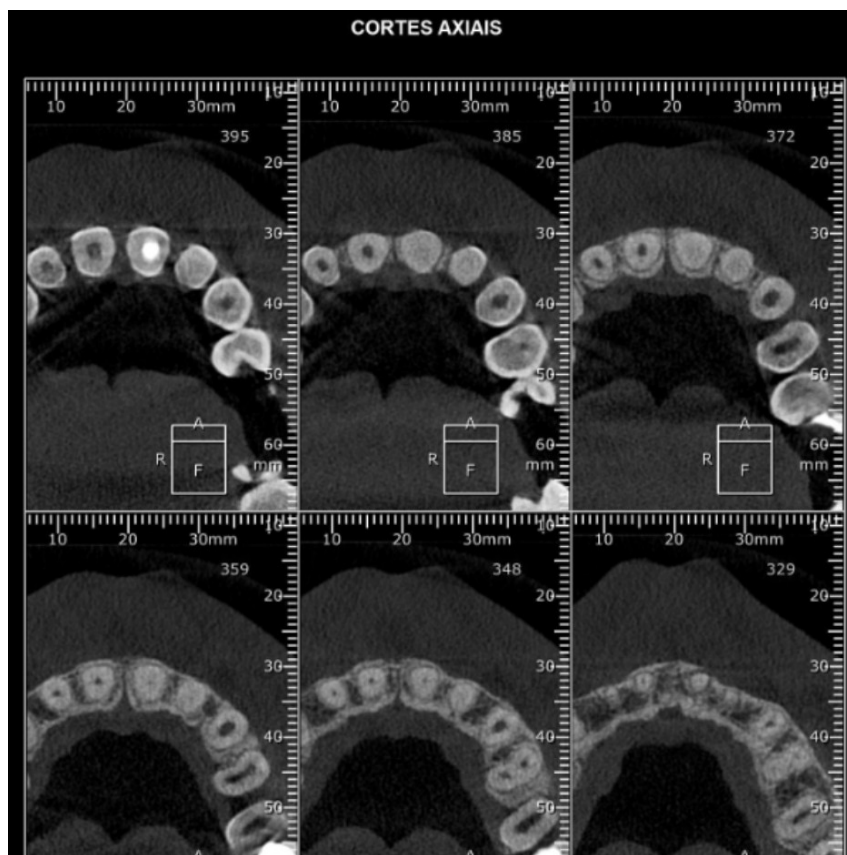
Diagnostic radiography
